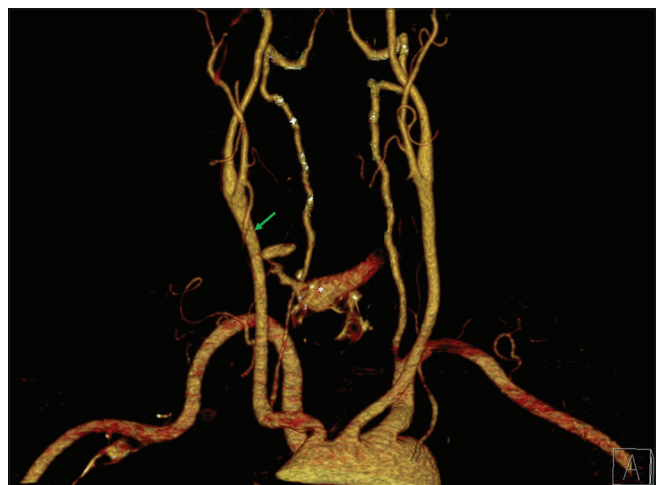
3D CT angiography reconstruction of the epi-aortic arterial vessels: the green arrow highlights the point of leakage (*) of the contrastum medium from the right superior thyroid artery.
